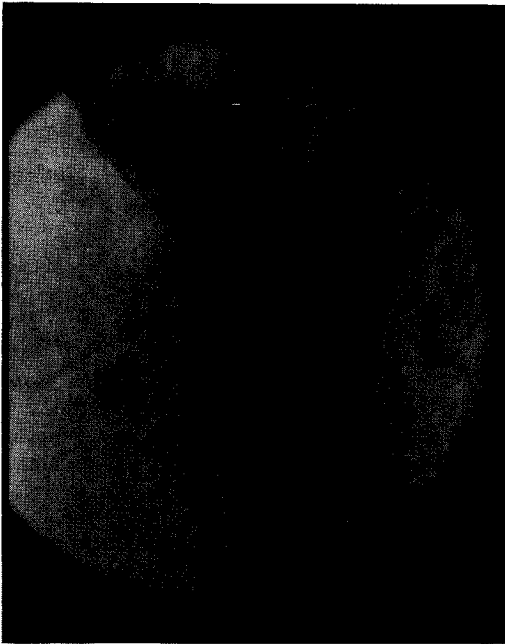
Radiograph of the genital tract of a harbour seal.
